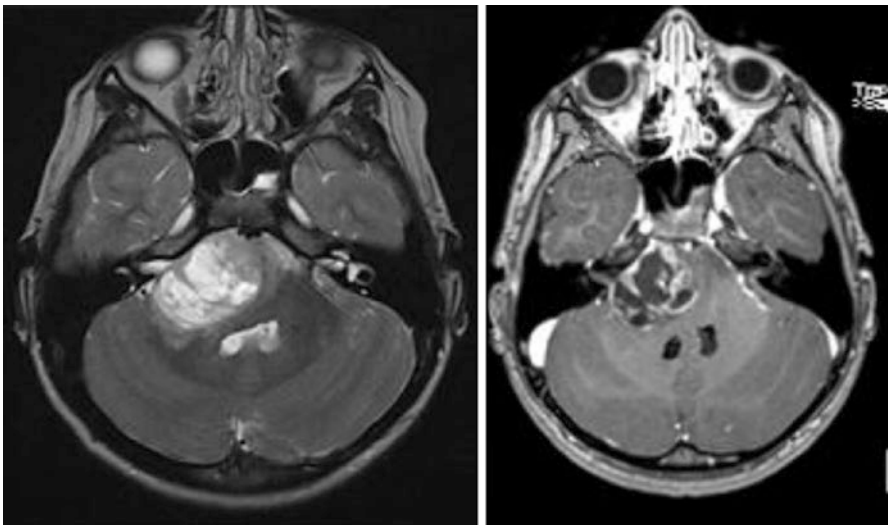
Diffuse intrinsic pontine glioma (DIPG). Axial T2 and T1 post-GAD MR images are depicted
